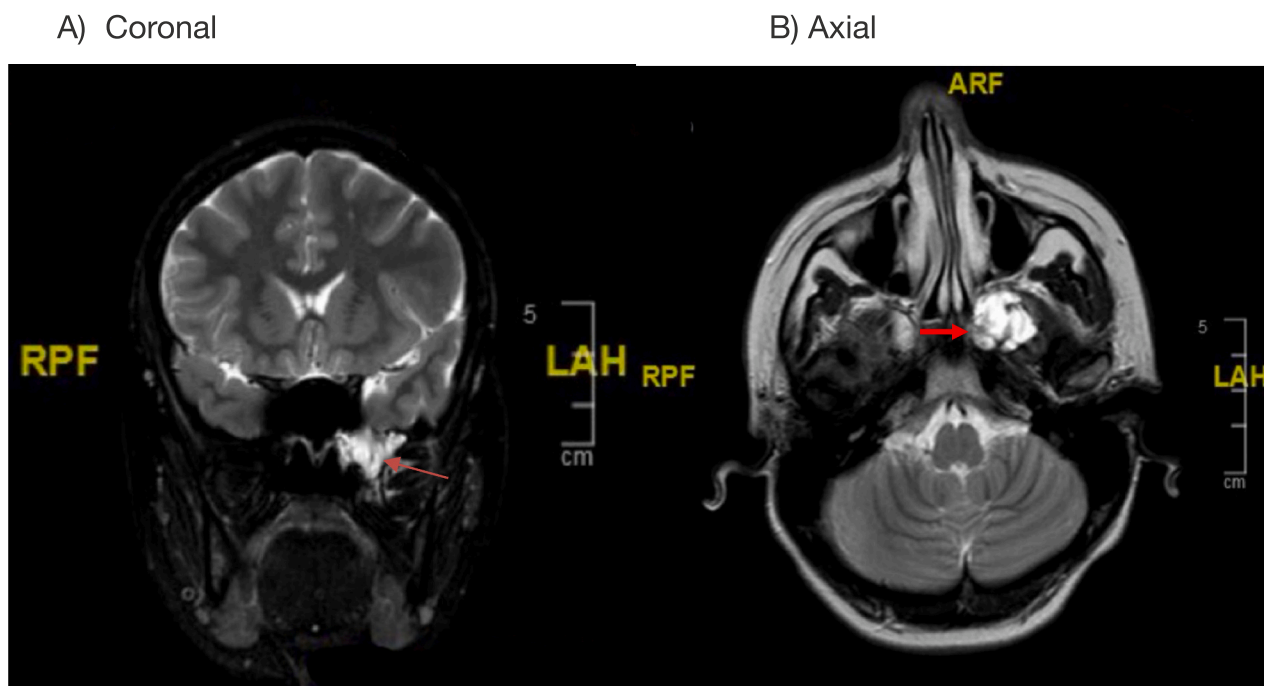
T2 weighted (T2W) MRI image showing a hyper-intense lesion in the left skull base involving the left greater wing of sphenoid and pterygoid causing a defect in the base of the left middle cranial fossa toward the cavernous sinus.
